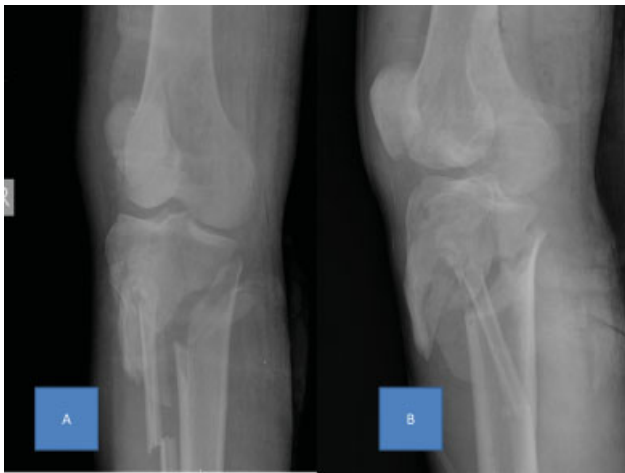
and 2B Preoperative anteroposterior and lateral radiographs of Patient 9.
